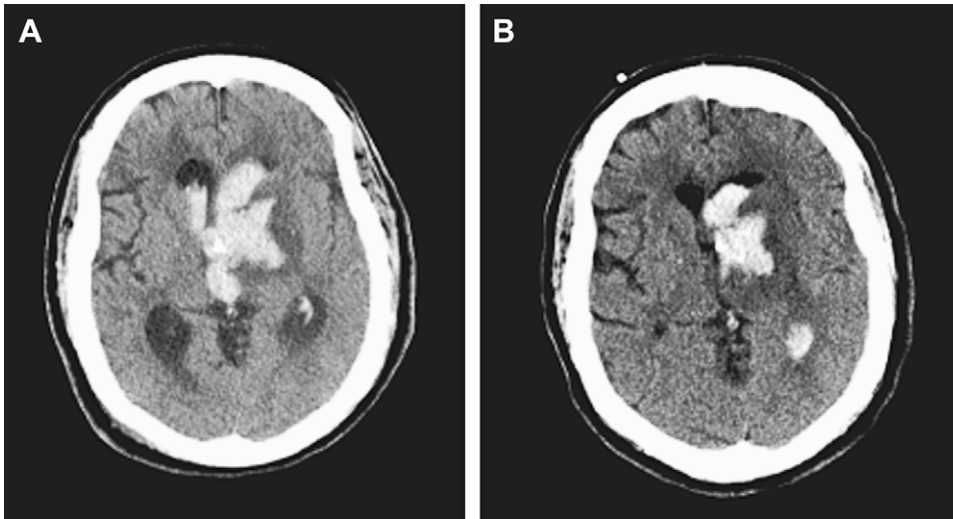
CT axial images demonstrating decreased IVH and improved EVD with intrathecal r-tPA without any evidence of re-hemorrhage. (A) Preintrathecal r-tPA infusion with dense IVH in bilateral frontal horns and third ventricle. (B) Postintrathecal r-tPA infusion with decreased IVH with complete resolution of right frontal horn and third ventricular IVH.
